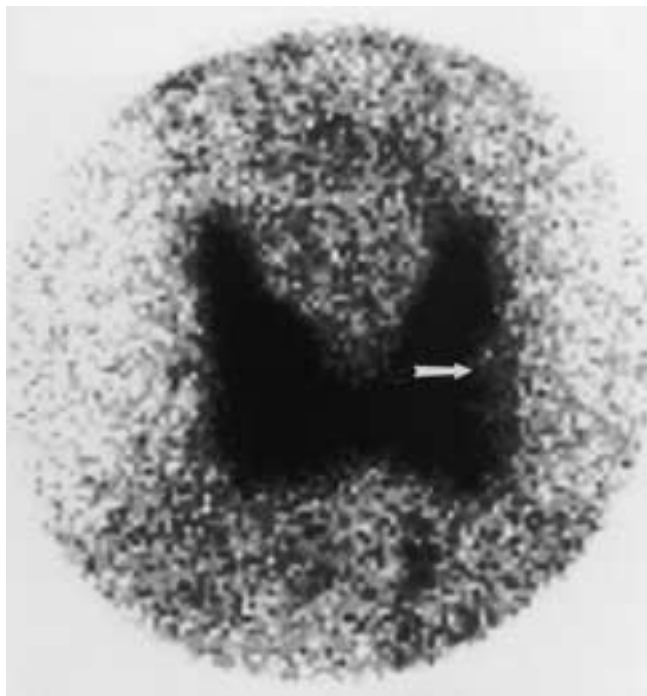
A 39-year-old male with a palpable thyroid nodule in the left thyroid gland. Nuclear scintigraphy shows a cold nodule (*arrow*) in the lateral aspect of the left lobe of the thyroid. Subsequent biopsy revealed follicular carcinoma. (Courtesy of Dr. Joseph Sam, Department of Radiology, Nuclear Medicine Division, University of Pennsylvania Medical Center.)
